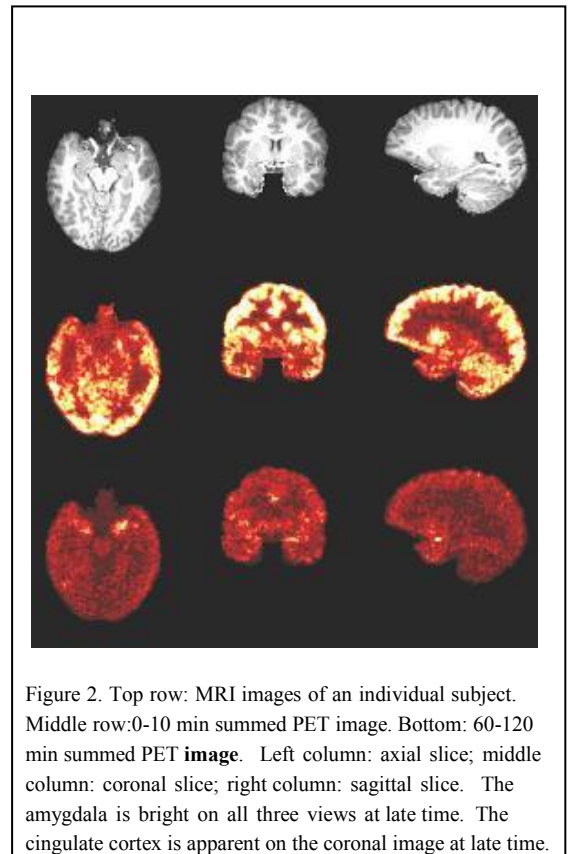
Top row: MRI images of an individual subject. Middle row: 0-10 min summed PET image. Bottom: 60-120 min summed PET image. Left column: axial slice; middle column: coronal slice; right column: sagittal slice. The amygdala is bright on all three views at late time. The cingulate cortex is apparent on the coronal image at late time.
